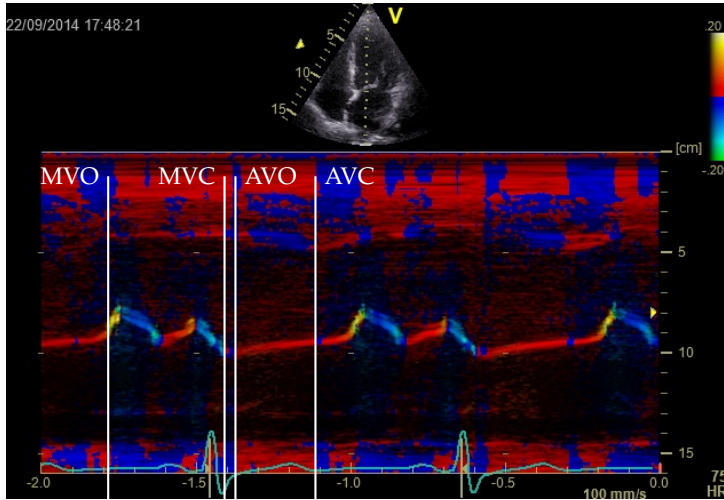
M-mode tissue doppler echocardiogram from participant of the study (N24). The white vertical lines indicate the four physiological events: mitral valve opening (MVO), mitral valve closure (MVC), aorta valve opening (AVO) and aorta valve closure (AVC) is annotated with the white vertical lines.
